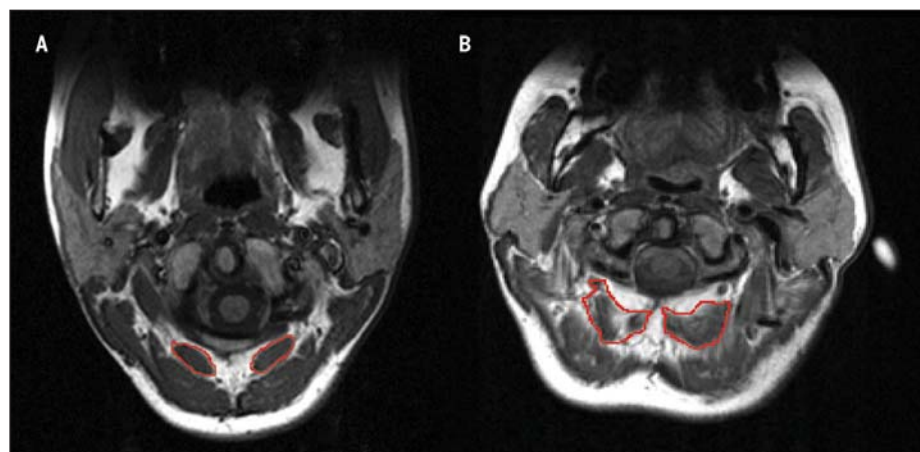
Bilateral axial magnetic resonance images of the rectus capitis posterior minor muscle (outlined in red) at Occiput-C1 (healthy control [A] compared to a subject with whiplash-associated disorder [WAD] [B]). Reproduced from Elliott J, Jull G, Notoom JT, Darnell R, Galloway G, Gibbon WW. Fatty infiltration in the cervical extensor muscles in persistent whiplash-associated disorders: a magnetic resonance imaging analysis. *Spine*. 2006;31:E847-855. Reprinted with permission from Lippincott, Williams & Wilkins.
